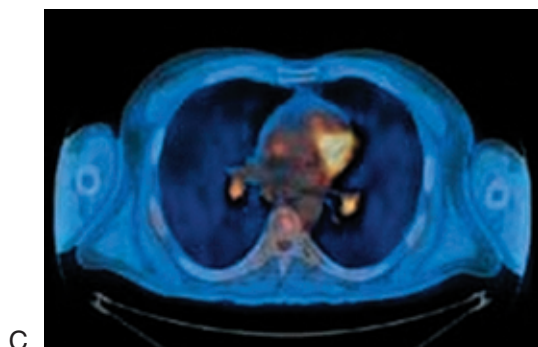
cont'd.* (C) PET/CT fused image correlating increased metabolic activity within lymph node masses implying pathological enlargement. Courtesy: Nuclear Medicine, University Hospital, Zurich, Switzerland.
